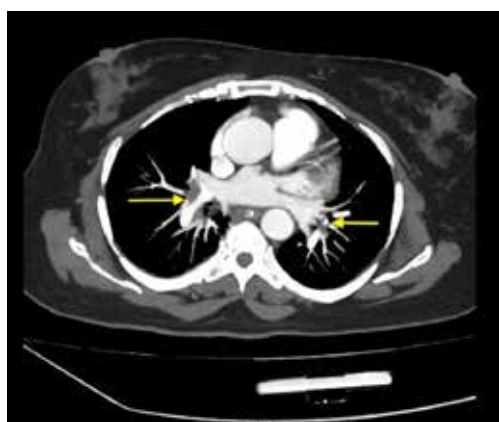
Axial view of computed tomography pulmonary angiography showing non-enhancing filling defects in distal most part of right and left main pulmonary arteries (yellow arrow)
